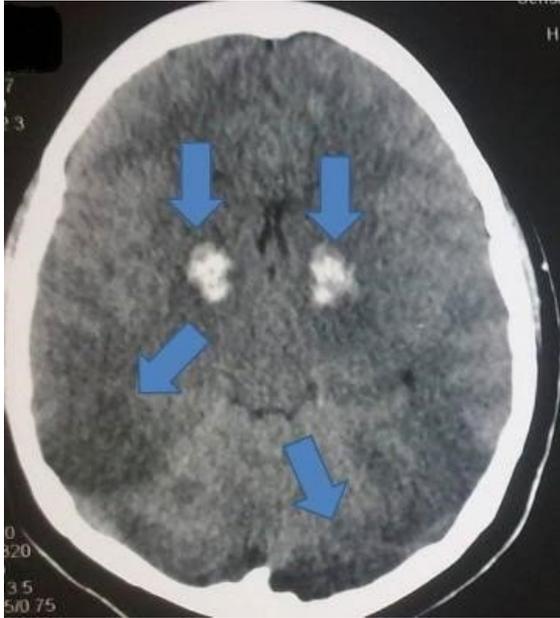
Cranial CT, day 6, bilateral deep white-matter symmetrical diffuse density lowering, bilateral hiperdensity hemorrhage fields at globus pallidus areas.
